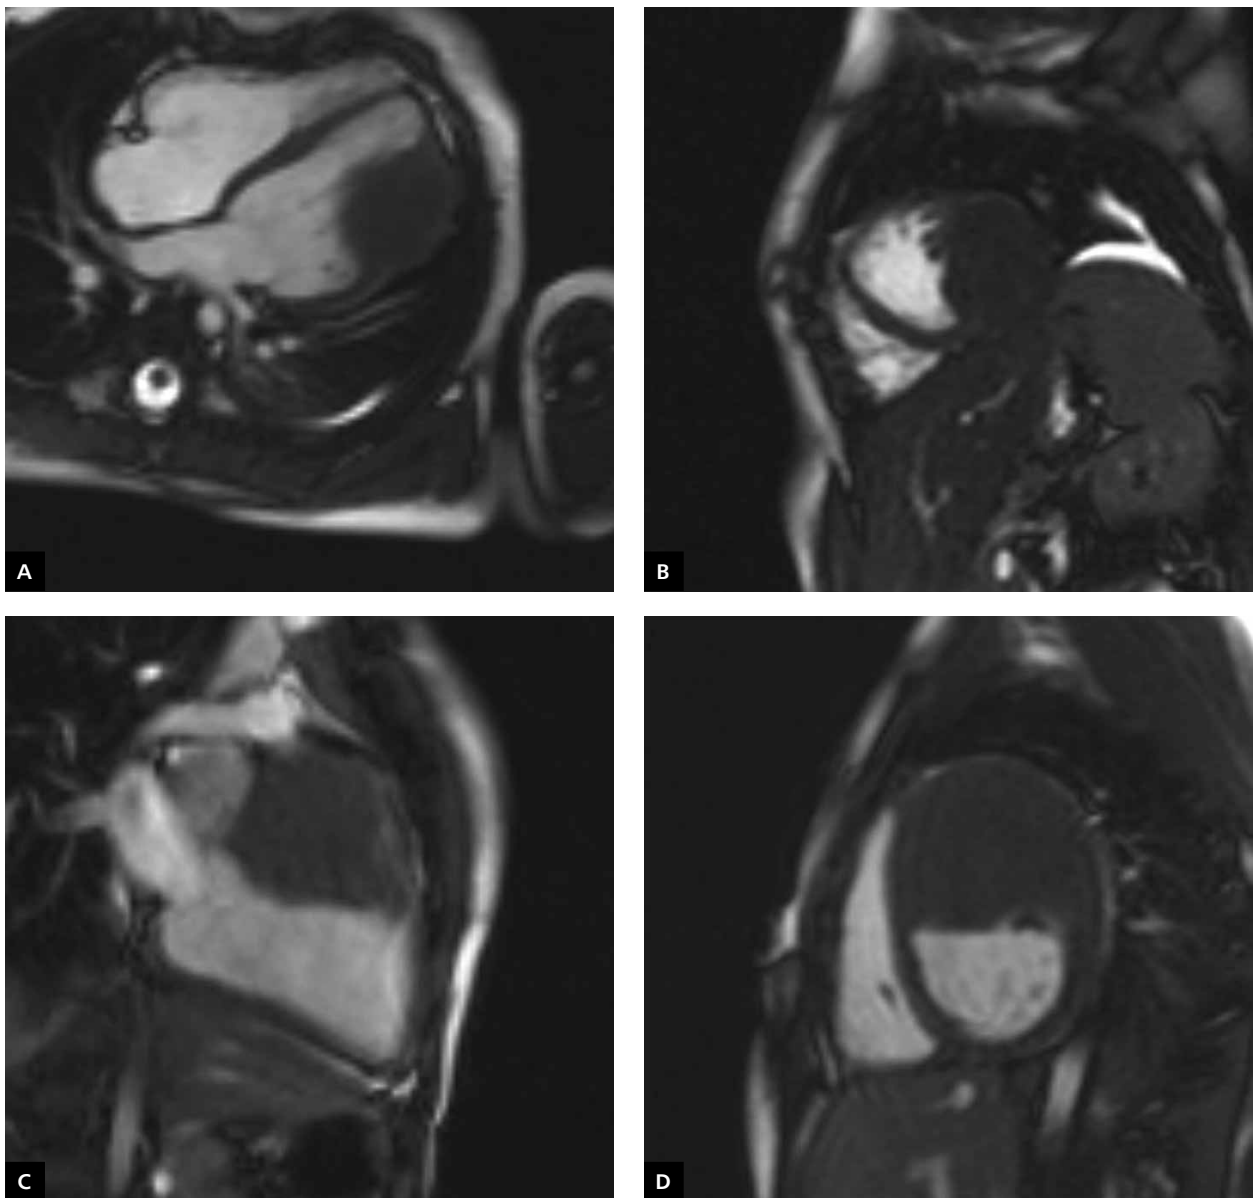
Cardiac magnetic resonance images in patients with cardiac tumours; A. Four-chamber view, cine SSFP sequence. Large tumour of the lateral wall is seen; B. Short-axis view in the same patient, cine SSFP sequence; C. Four-chamber view, cine SSFP sequence. Large tumour of the anterior wall is seen; D. Short-axis view in the same patient, cine SSFP sequence
